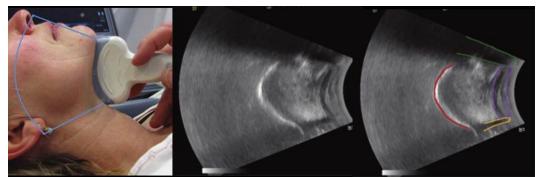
Longitudinal scan of the floor of the mouth and the tongue. Left, Placement of the curved low-frequency transducer. The area covered by the scan is outlined in light blue. Middle, The resulting ultrasound image. Right, The shadow from the mentum of the mandible is outlined in green, the muscles in the floor of the mouth in purple, the shadow from the hyoid bone in light orange, and the dorsal surface of the tongue in red (23).
